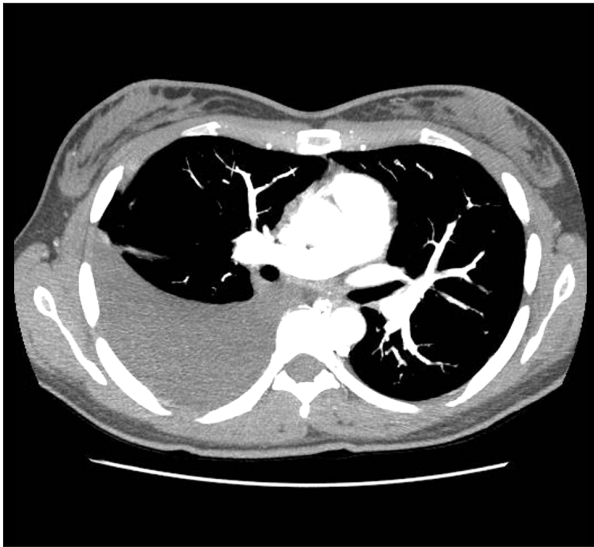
Computed tomography pulmonary angiography – Sample CT image slice depicting extensive pulmonary emboli.
